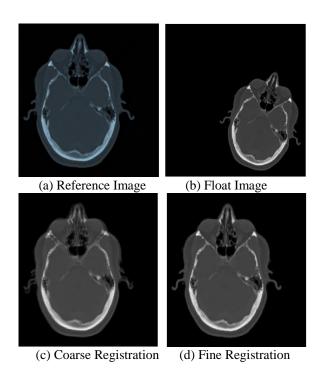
Registration between CT Images for upscaling
